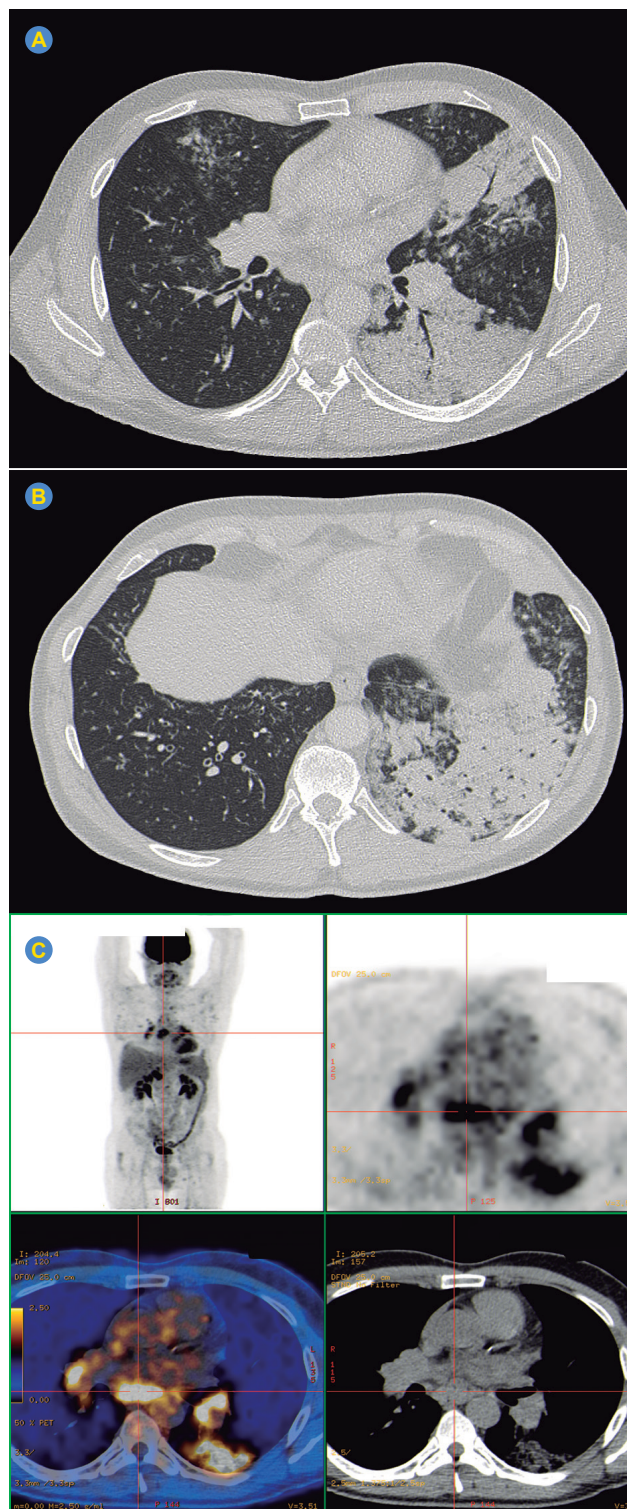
Chest CT showing multifocal consolidation involving almost the entire left lower lobe and lingula, comprising approximately 50% of the left lung, as well as numerous bilateral ground-glass opacities (A) (B). PET-CT showing increased metabolic uptake in the left upper and lower lobes, right middle lobe, and bilateral lymph stations (10L, 7, 4L, 10R) (C).
